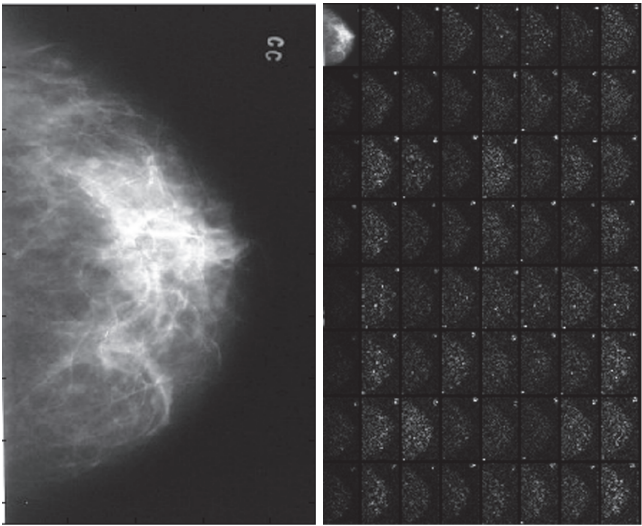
An image of X-ray mammogram (left) and its complete decomposition using Daubechies’s db4 wavelet.
